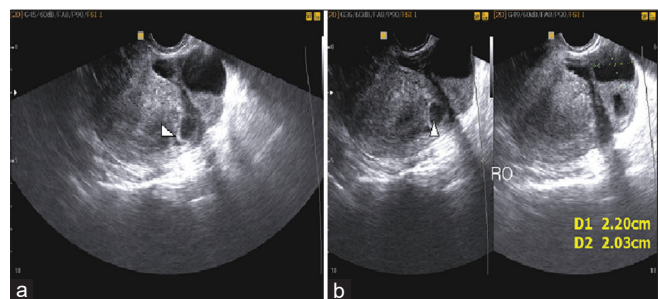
(a and b) Transvaginal ultrasound showing ectopic gestational sac (arrow head) observed at the right uterine cornu with thin overlying myometrium and was associated with small right ovary cyst
